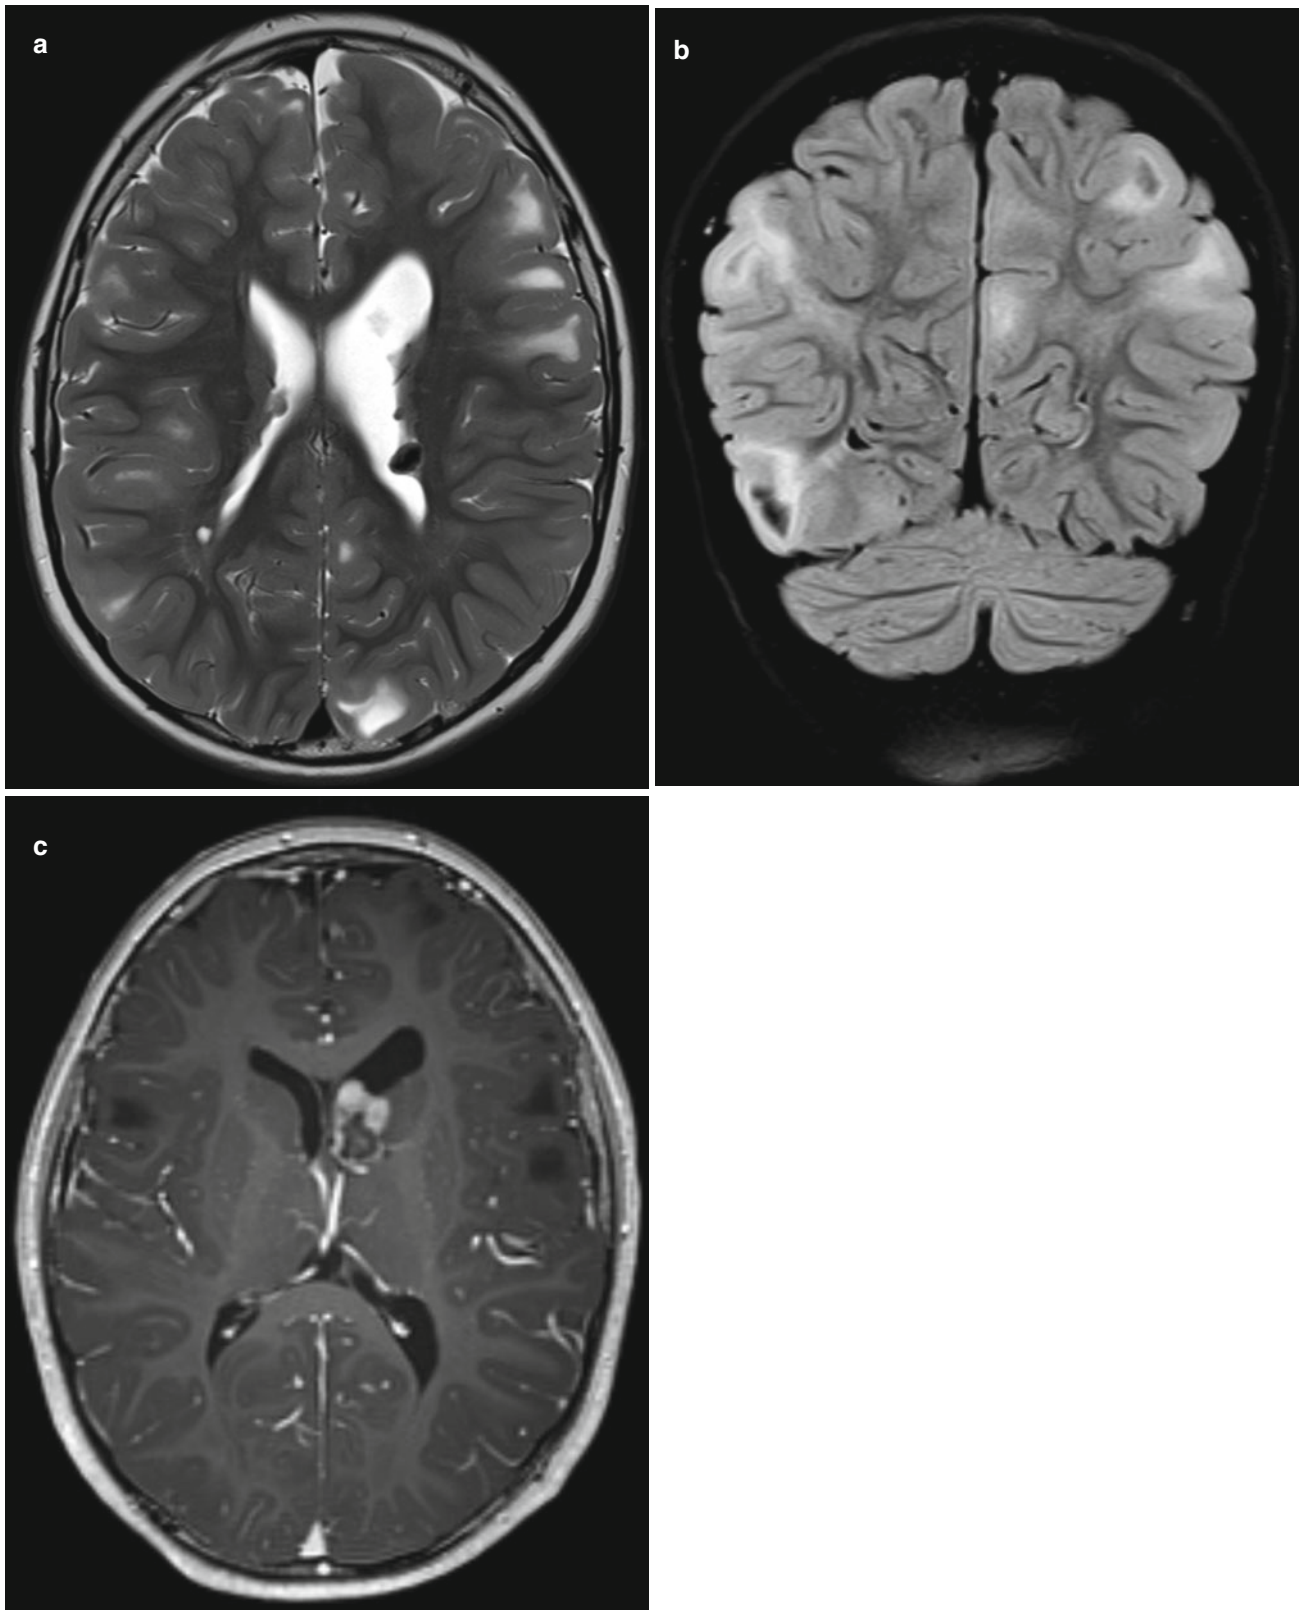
(a–c) Tuberos sclerosis; (a) axial T2 and (b): coronal T2/FLAIR show subependymal hamartomas and widespread cortical and subcortical signal changes; (c) axial T1 with gadolinium with a large
